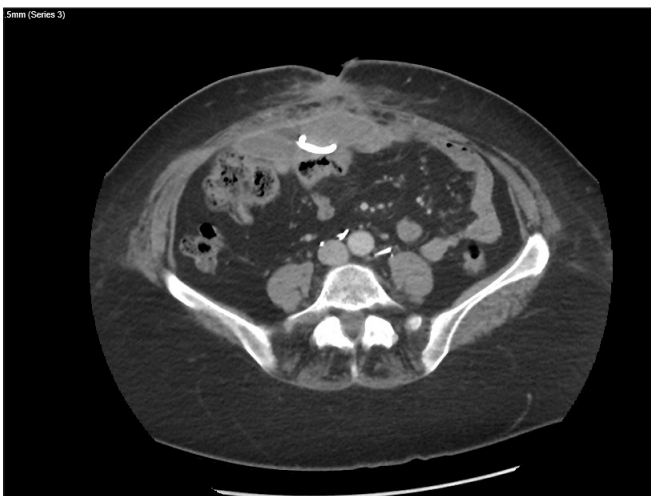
Abdominal computed tomography scan obtained 1 month before prosthetic mesh explantation showing an intra-abdominal abscess measuring 9.5 cm × 2.3 cm deep within the abdominal wall and containing a few bubbles of gas. Percutaneous drains are seemingly well positioned.
